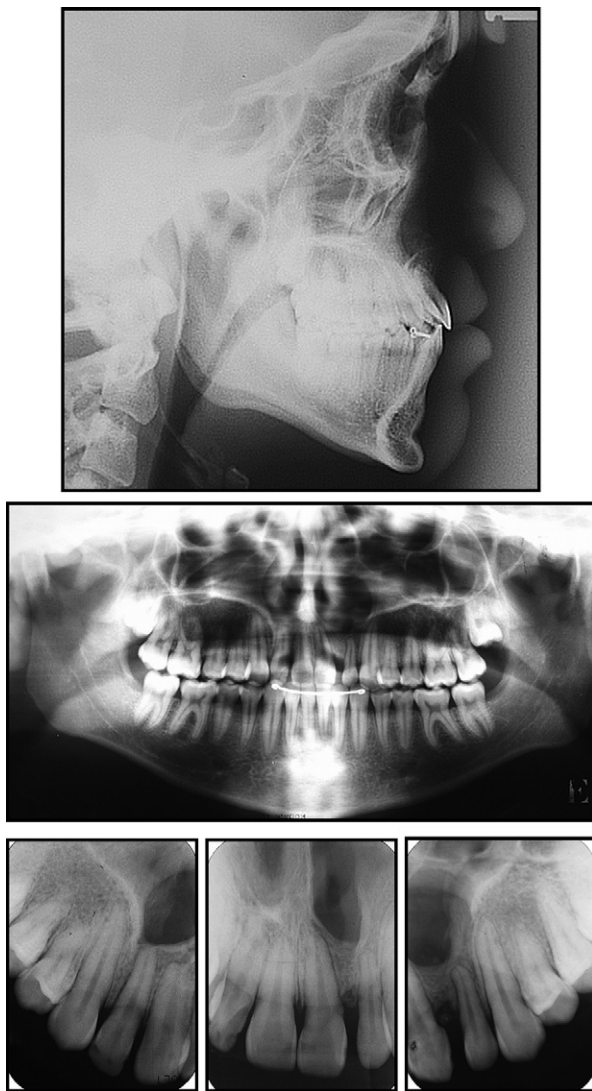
Posttreatment cephalometric, panoramic, and periapical radiographs.
